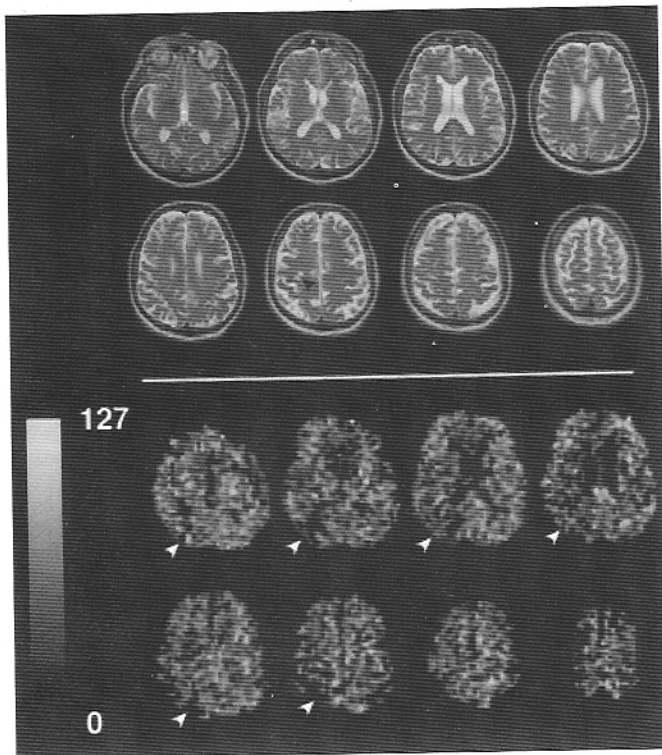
Cerebral blood flow (CBF) images and T2-weighted images from Patient 10. (Top) T2-weighted images show subcortical ischemic changes in the right parietal lobe abutting the motor cortex (black arrow). (Bottom) CBF images show more widespread hypoperfusion in the right posterior watershed distribution (white arrows). Grayscale shows CBF ranging from 0 to 127 mL/100 g/min.
